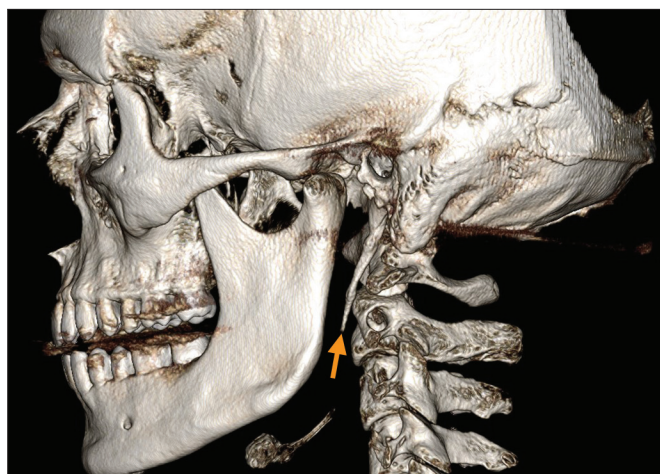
An oblique view of a 3-D reconstruction from cone-beam computed tomography showing the left cervical/cranial region with an elongated styloid process (arrow), diagnosed as "Eagle syndrome" or "stylohyoid syndrome" and sometimes referred to as "styalgia" when painful.
